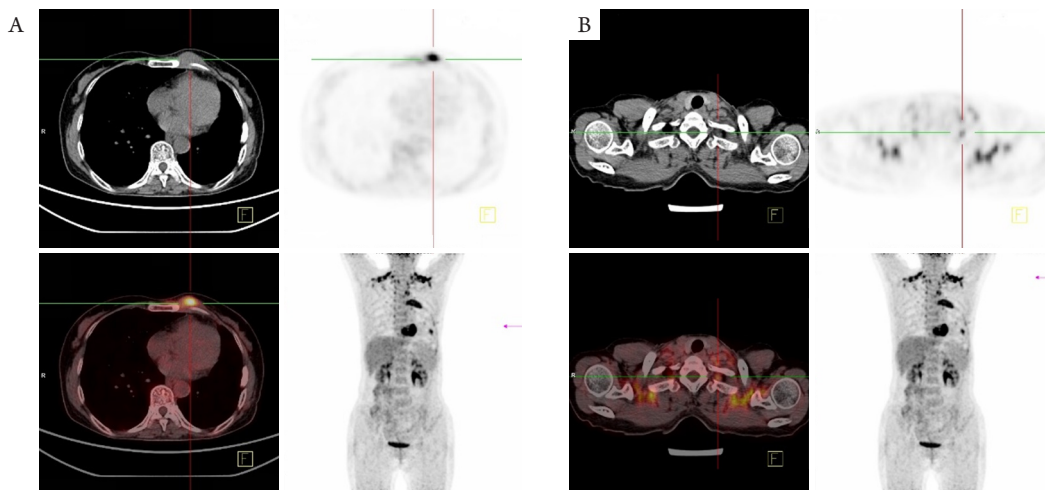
PET/CT显示胸骨左侧旁结节状软组织影放射性分布浓聚, 最大标准摄取值(SUVmax)约为15.1, 与周围肋骨组织关系密切; 左肺上叶舌段见斑片状高密度影放射性分布较浓聚, SUVmax约5.3
